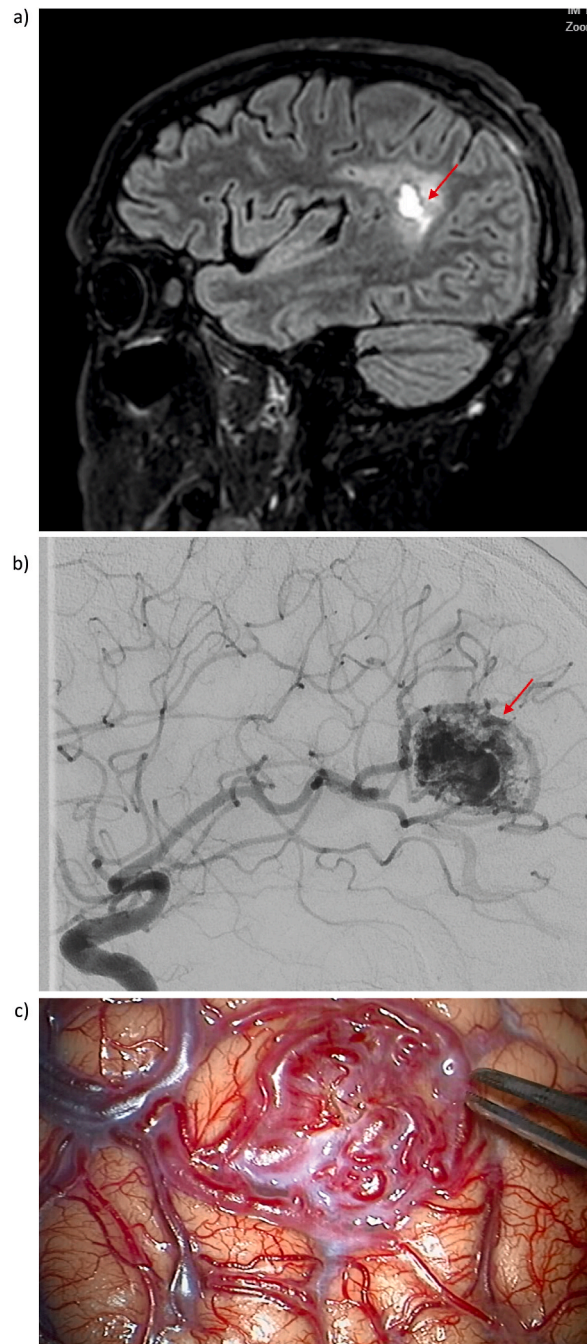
Clinical features of bAVM lesion. a) MRI evidence of the lesion (indicated by the red arrow) in the right parietal area. b) Cerebral angiography for bAVM diagnosis confirmation. c) Microsurgical removal of the bAVM lesion.
